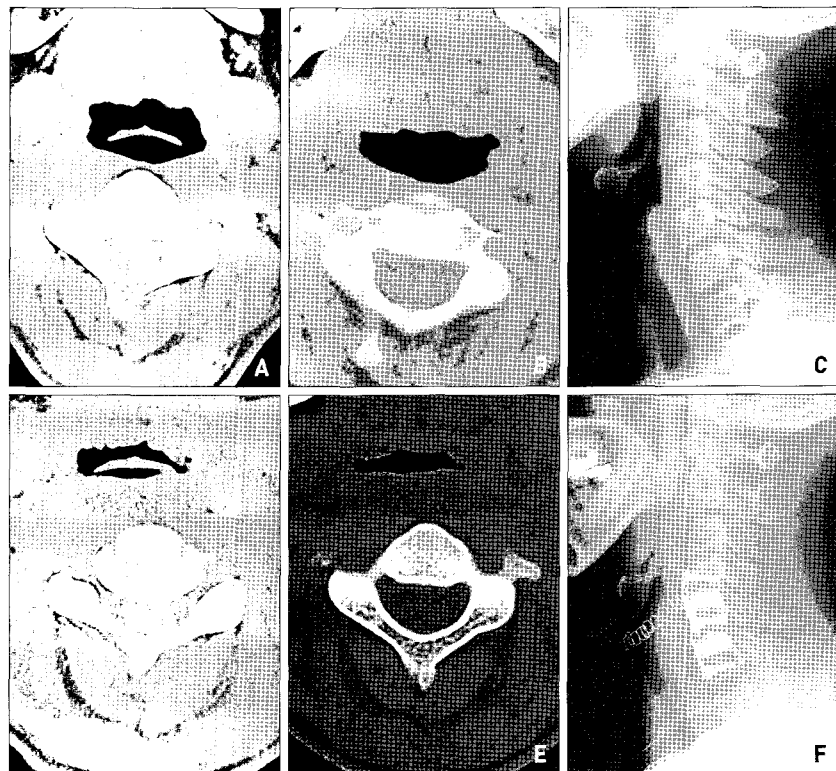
A 52-year-old female who had severe airway narrowing and prevertebral soft tissue swelling but no definite respiratory complication. Compared with preoperative state, airway narrowing and prevertebral soft tissue swelling are maximum on 2nd operation day. CT scan revealed markedly narrowed AP airway diameter but transection diameter was not severely narrowed despite prevertebral soft tissue swelling. (A : Preoperative C-spine CT scan at above epiglottis, B : Preoperative C-spine CT scan at epiglottis level, C : Preoperative simple lateral film, D : 2nd operation day CT scan on above epiglottis, E : 2nd operation day simple X-ray film, F : 2nd operation day CT scan near epiglottis).
